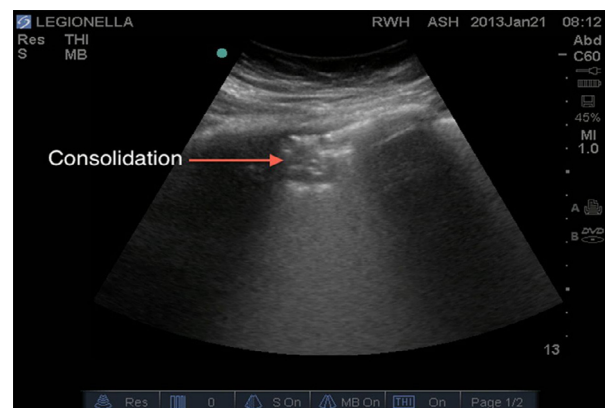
Lung ultrasound image showing a small anterior consolidation area with indistinct margins (red arrow). Reprinted with permission from Miller (2016).
